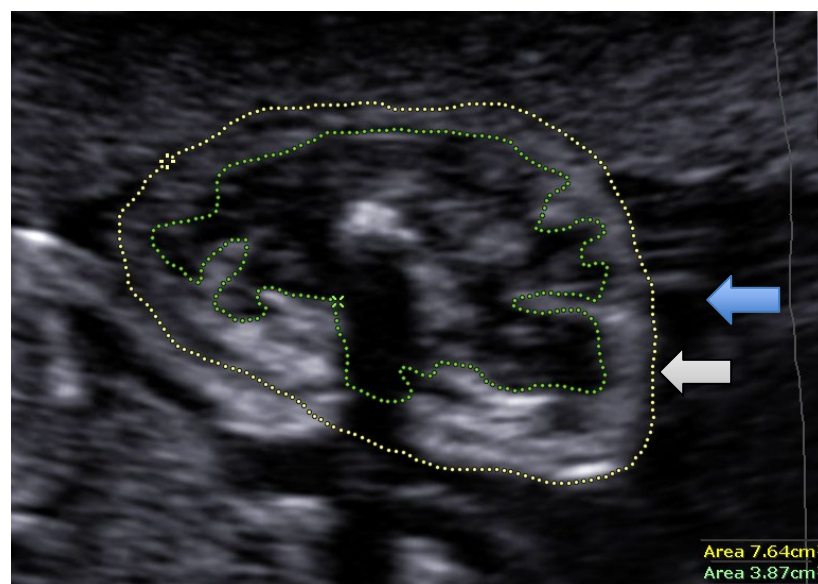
Ultrasound image of fetal mid-thigh total mass (MTTM; blue arrow), mid-thigh fat mass (MTFM; white arrow), and mid-thigh lean mass (MTLM). Participant image used with permission.
